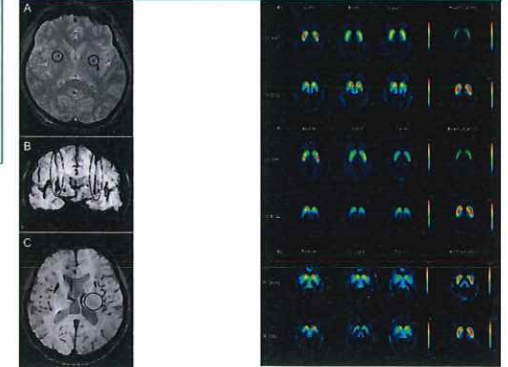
Brain MR images of a grafted patient. A. T2 axial image showing the 2 sites of placement of an NPC suspension in either putamen (circles) at 24 h post-surgery. B. SWAN coronal image showing both implant trajectory paths to either putamen (ellipses) at one year post-surgery. C. T2 axial image at one year post-surgery showing robust graft outgrowth in the right putamen (circle) in P4 with no topographical abnormalities of the brain structures.
